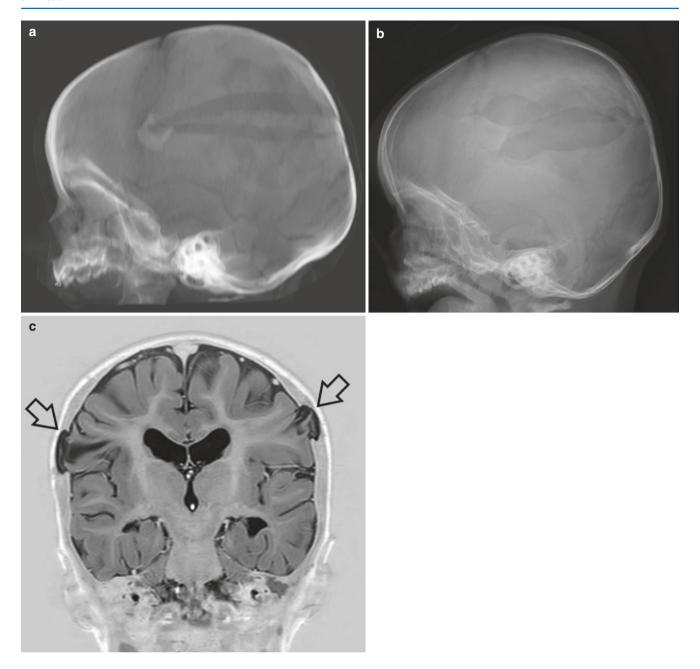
An infant who fell from the hands of the caretaker. (a) radiograph shows bilateral diastatic parietal fractures. (b) At the age of 6 months the fractures have increased in width due to (c) herniation of intracranial structures into the fractures (arrows)
